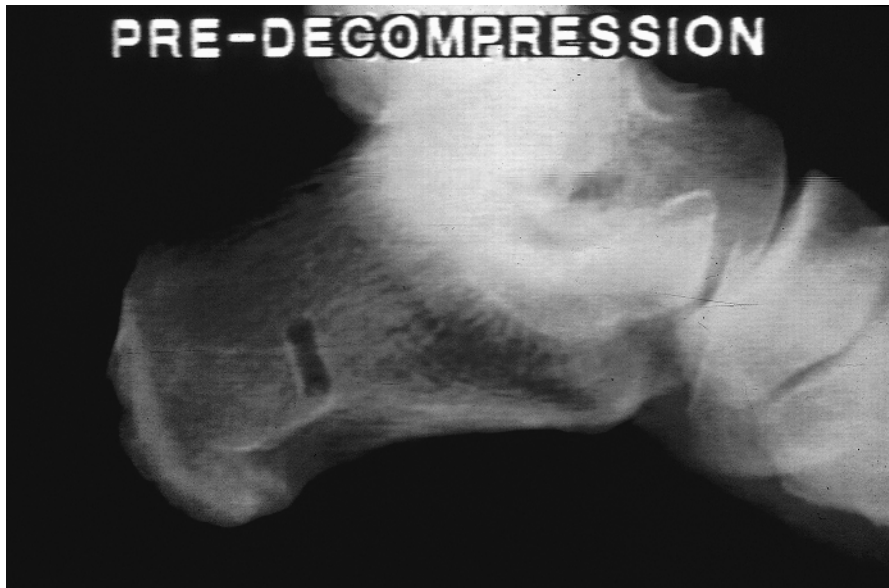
Preoperative lateral radiograph of a patient with symptomatic retrocalcaneal bursitis and a prominent posterosuperior calcaneal tuberosity. (Courtesy of T. Zimmer.)
